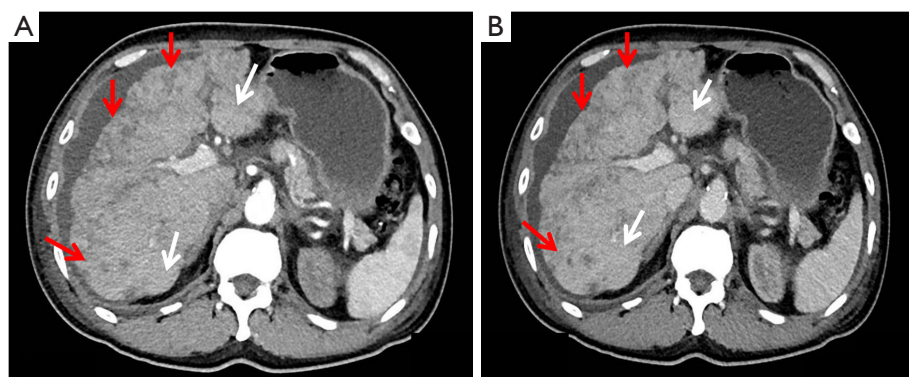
Computed tomography of the abdomen demonstrating the liver volume decreased and metastatic lesions enlarged in the liver. (A) Arterial phase, (B) venous phase: the liver volume decreased with treatment, and the metastatic lesions in the liver progressed (metastatic tumors, red arrows; cirrhotic regenerative nodules, white arrows); the nodule types were mixed and diffusely distributed throughout the liver.
